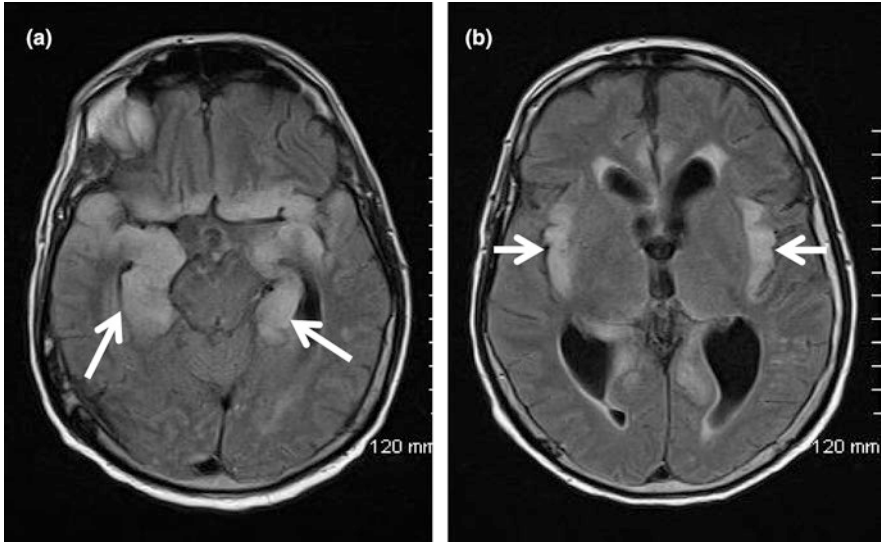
Two images of the T2 FLAIR sequence from an MRI brain performed for a patient with encephalitis. a Hyperintense signal in both temporal lobes and hippocampi (arrows). b Hyperintense signal in both insular cortices. The pattern of involvement of signal abnormality in this case is typical for HSV encephalitis
